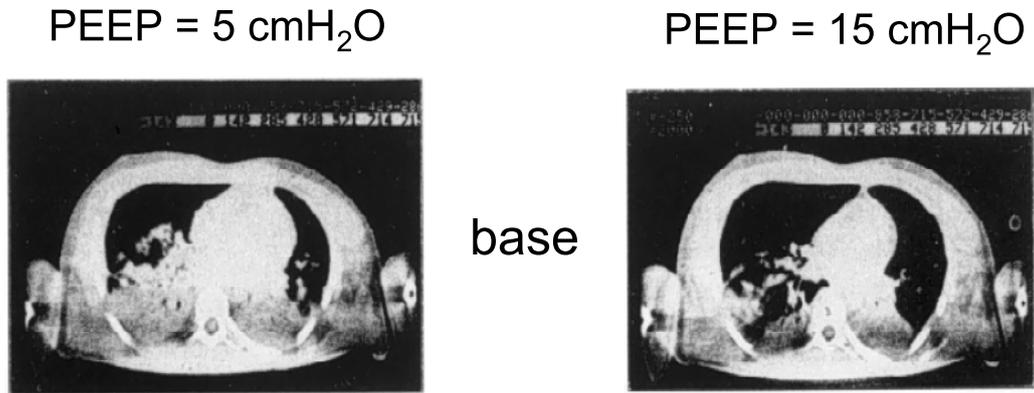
Single slice from a computed tomography scan of a patient with acute respiratory distress syndrome (ARDS) obtained at a positive end-expiratory pressure (PEEP) of 5 cm H₂O (left) and a PEEP of 15 cm H₂O (right). Note the inhomogeneous distribution of abnormalities, with consolidation, atelectasis, and fluid in the dependent lung zones, and relatively well-aerated lung in the nondependent zones. Note that increasing levels of PEEP recruited parts of the lung. (From Reference 6, with permission.)
